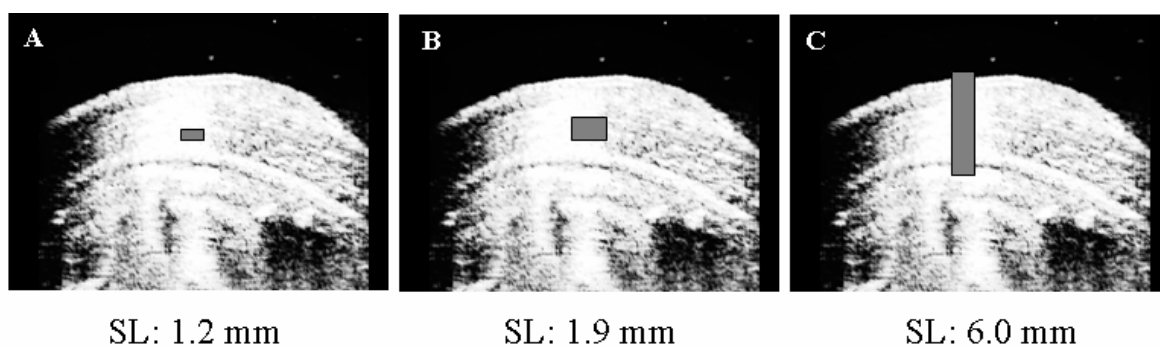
Ultrasonograms of the anterior antral wall. The grey box represents the strain length. In panel A, the strain length is too small to represent the whole wall thickness. In panel B, the strain length is appropriate for measuring average strain across the wall for this wall thickness. In panel C, the strain length is too big and extends far beyond the wall limits.
